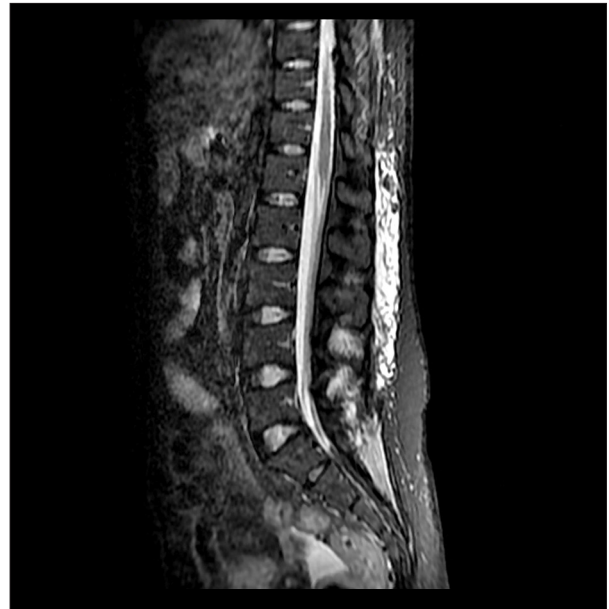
Sagittal T2-weighted MRI image showing regression of the conus medullaris lesion and the engorged epidural vessels presenting significant evidence suggesting DVT.
